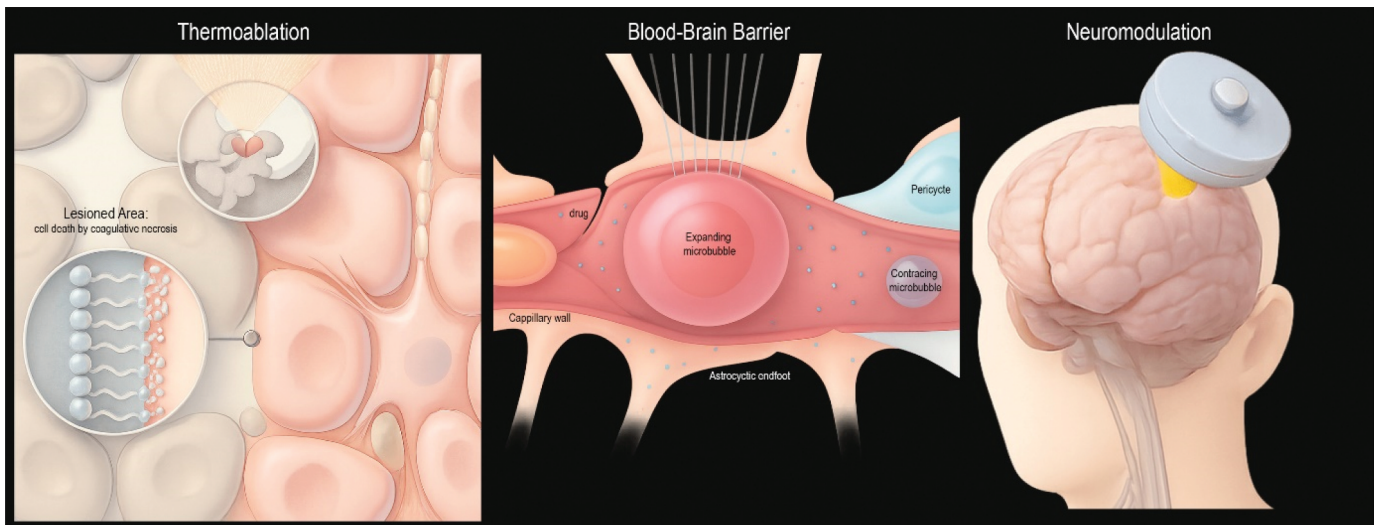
(Right panel) high intensity fTUS for thermoablation is magnetic resonance (MR) guided to enable real-time monitoring of the lesion and temperature during sonication, (middle panel) opening the blood-brain barrier by applying fTUS to target drug delivery, (left panel) transcranial ultrasound stimulation for neuromodulation.
